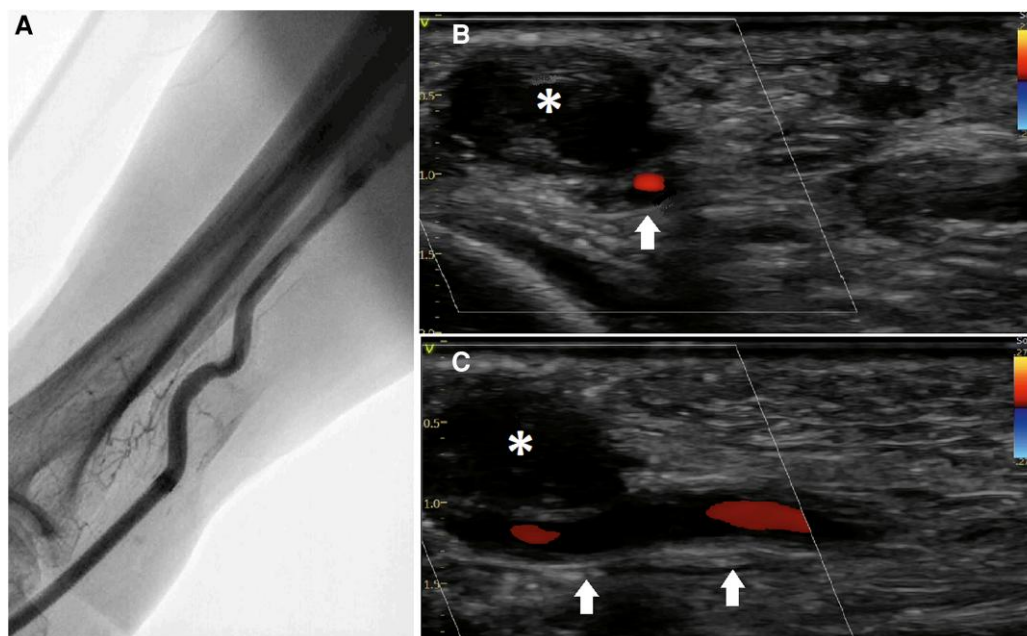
Angiographic and echographic visualization of the radial artery and the occluded pseudoaneurysm. A final angiography of the radial artery 24 h after compression confirmed completely occlusion of the neck feeding the pseudoaneurysm with a patent radial artery (A) while the echo colour Doppler evaluation had confirmed the same findings showing the partially thrombosed pseudoaneurysm (B and C). Asterisks indicate the pseudoaneurysm. Arrows point to the patent radial artery.
